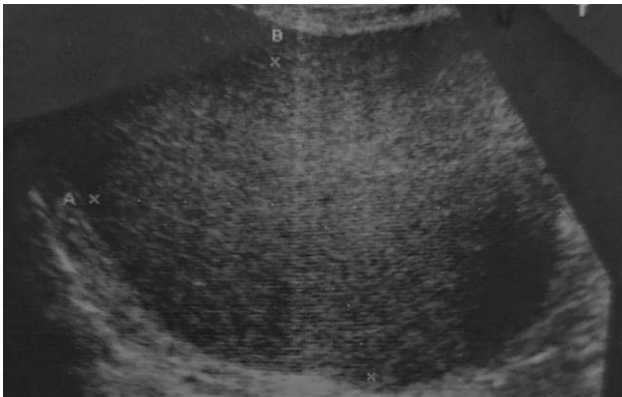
Ultrasonographic image showing a large hypoechoic solid lesion
